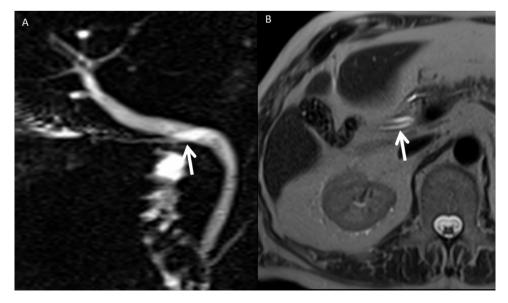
Coronal MRCP image (A) and axial T2 weighted MR image (B) showing low insertion of the cystic duct (white arrow) with parallel course to common bile duct >2 cm.
